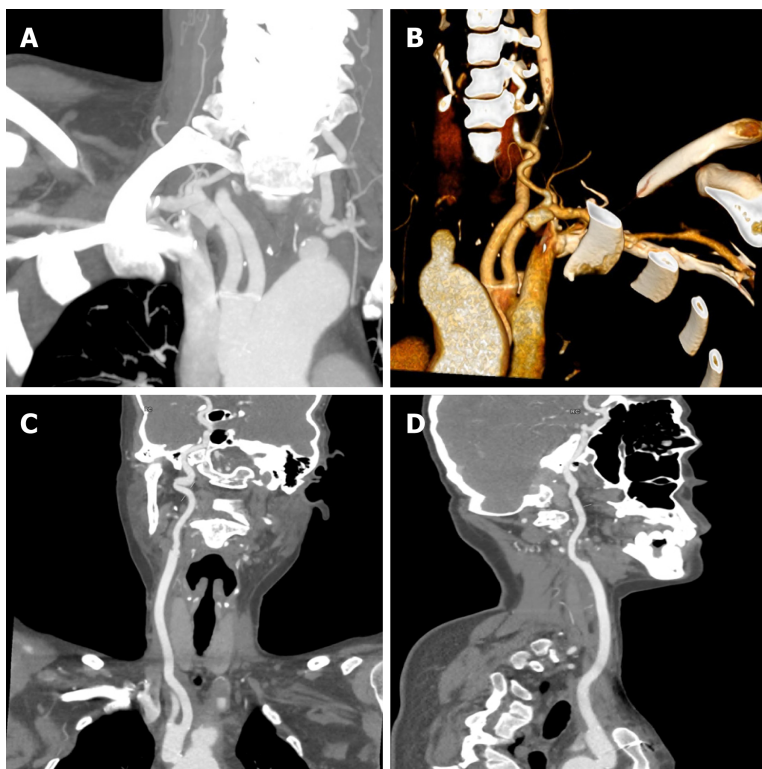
Computed tomography angiography images obtained 1 mo after surgery demonstrating patency of the artificial vessel with no dilatation.
